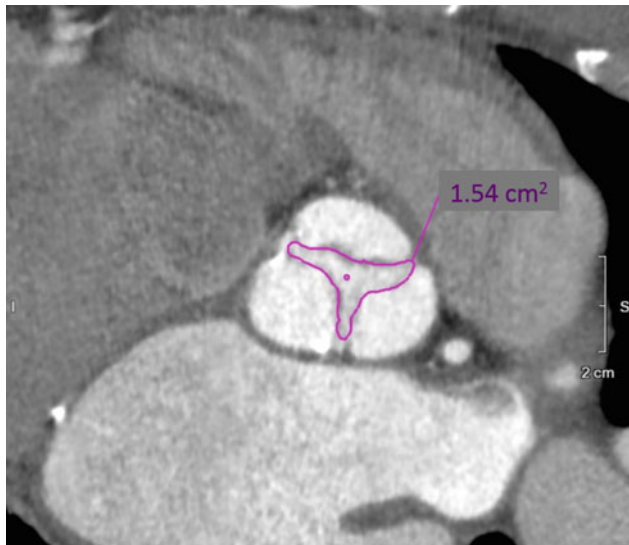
Cardiac computed tomography angiography at the level of the aortic valve in systole showing a planimetered aortic valve area of 1.54 cm². The corresponding aortic valve calcium score was 1645 Agatston units
